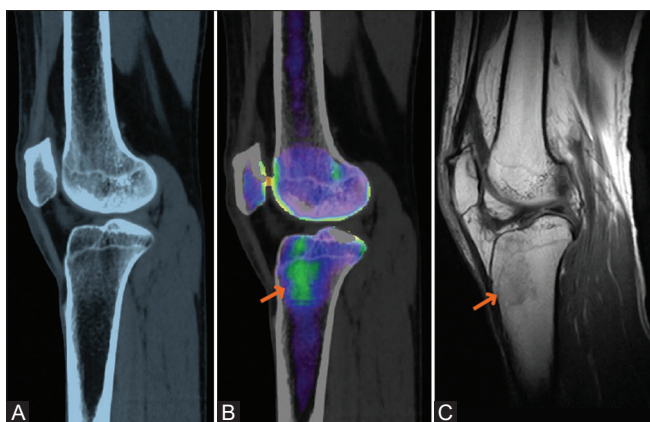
(A-C): (A) Sagittal views of a CT image of the right knee joint of a patient with bone marrow edema on the lateral aspect of the proximal tibia. (B) Sagittal views of a DE VNCa image of the right knee joint show bone marrow edema (arrows) on the lateral aspect of the proximal tibia. (C) Sagittal views of a T1-weighted MR [C] image of the right knee joint show bone marrow edema (arrows) on the lateral aspect of the proximal tibia
